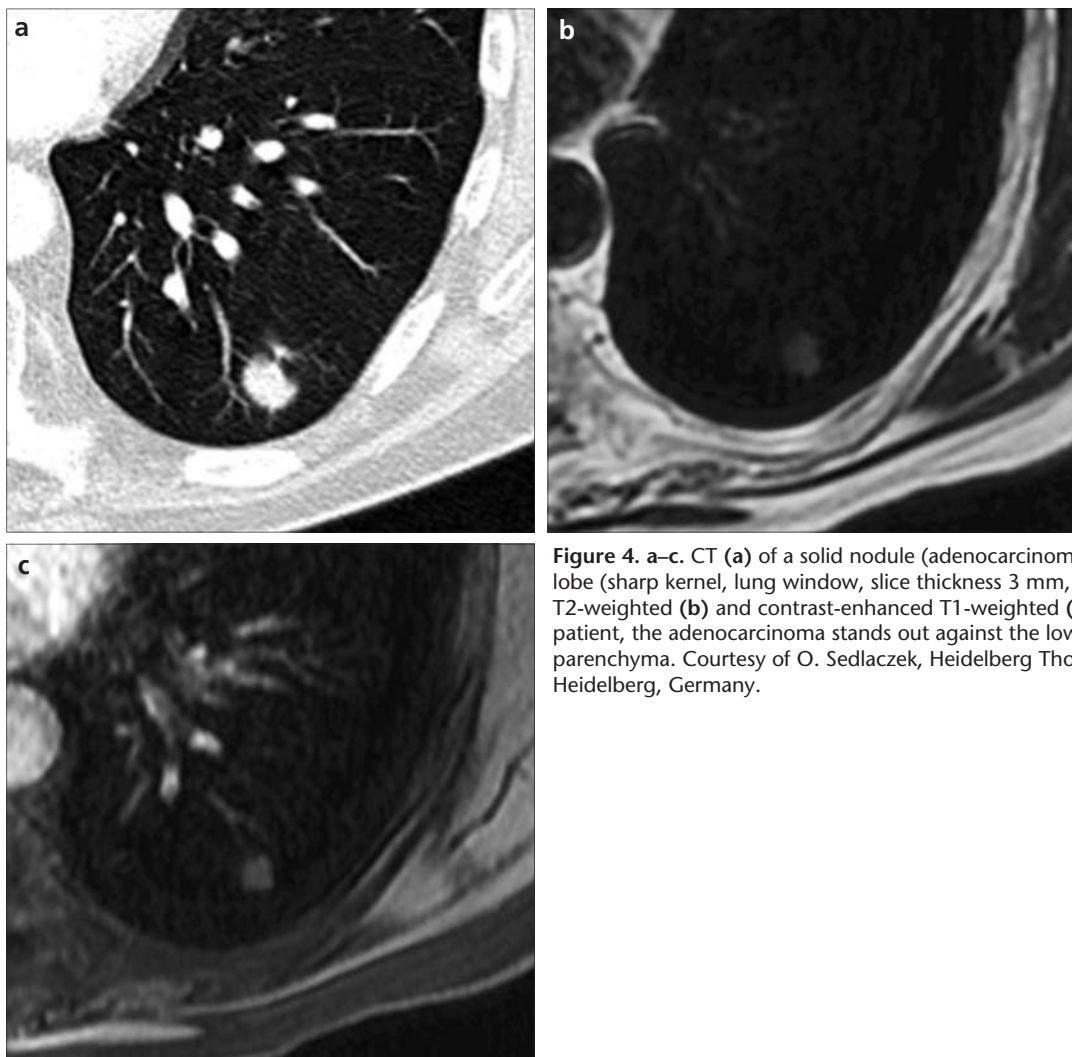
a–c. CT (a) of a solid nodule (adenocarcinoma) within the left inferior lobe (sharp kernel, lung window, slice thickness 3 mm, increment 2 mm). On the T2-weighted (b) and contrast-enhanced T1-weighted (c) sequences of the same patient, the adenocarcinoma stands out against the low signal intensity of the lung parenchyma. Courtesy of O. Sedlaczek, Heidelberg Thoracic Imaging Platform, Heidelberg, Germany.
